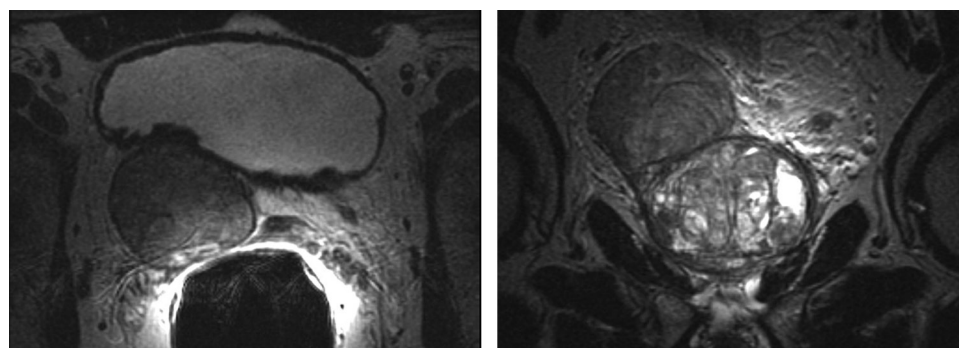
BPH in a 60-year-old man with an elevated PSA level. Digital rectal examination disclosed a palpable nodule, and an MR imaging examination was ordered for further evaluation. Axial (a) and coronal (b) T2-weighted MR images show a circumscribed hypointense slightly heterogeneous encapsulated nodule, a finding consistent with BPH. The patient underwent systematic transrectal US-guided biopsy, which included sampling of the nodule, but no cancer was detected.
